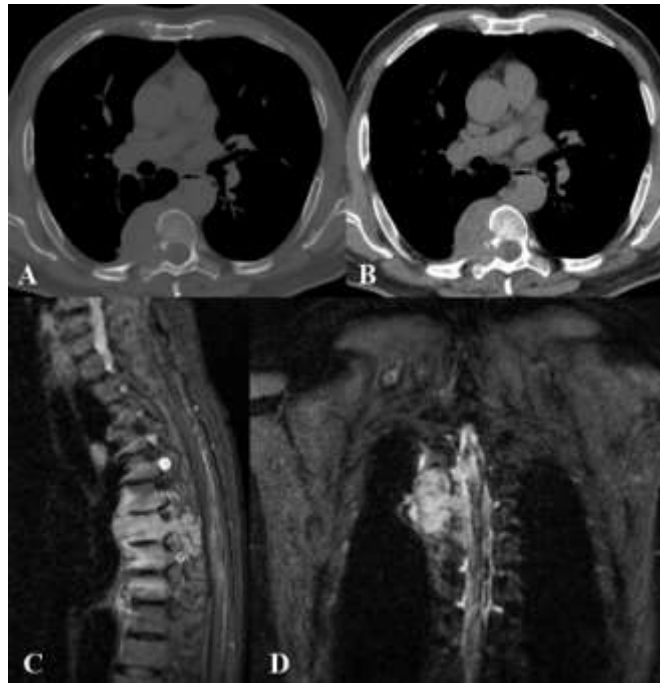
Spindle cell sarcoma in a 64 years old male patient. Axial CT images (A, B) show inhomogeneous soft tissue density, resulting in erosion of the cortical of the right D7 hemisoma, right D7 lamina, head and neck of the right 7th rib. Invasion and enlargement of the correspondent neural foramen with compression of the spinal cord. MRI (C, D) shows a coarse heteroplastic mass in the right posterior paravertebral region, at the level of the costovertebral angle, between D6-D8, showing hypointense T1 signal and inhomogeneous enhancement after intravenous administration of gadolinium. This lesion infiltrates the right hemiportion of the posterior arch and soma of D7, extends to intervertebral foramina and shows the absence of cleavage plane with ipsilateral pleura.
